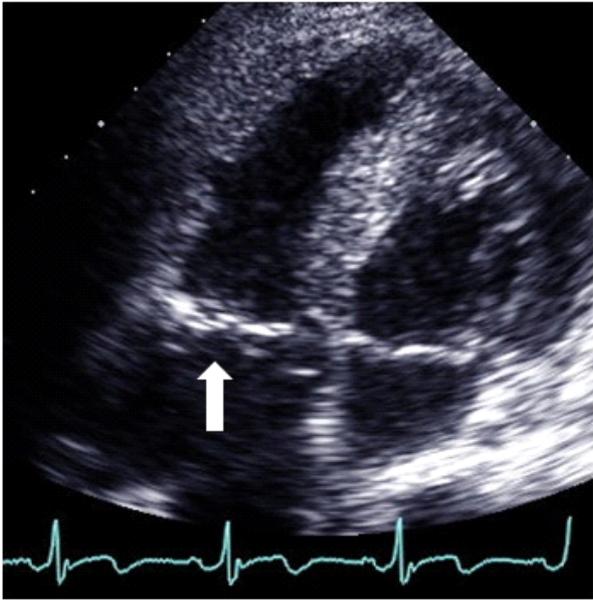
Echocardiography showed well coapted tricuspid valve leaflets (arrow) at the 7th postoperative day.
